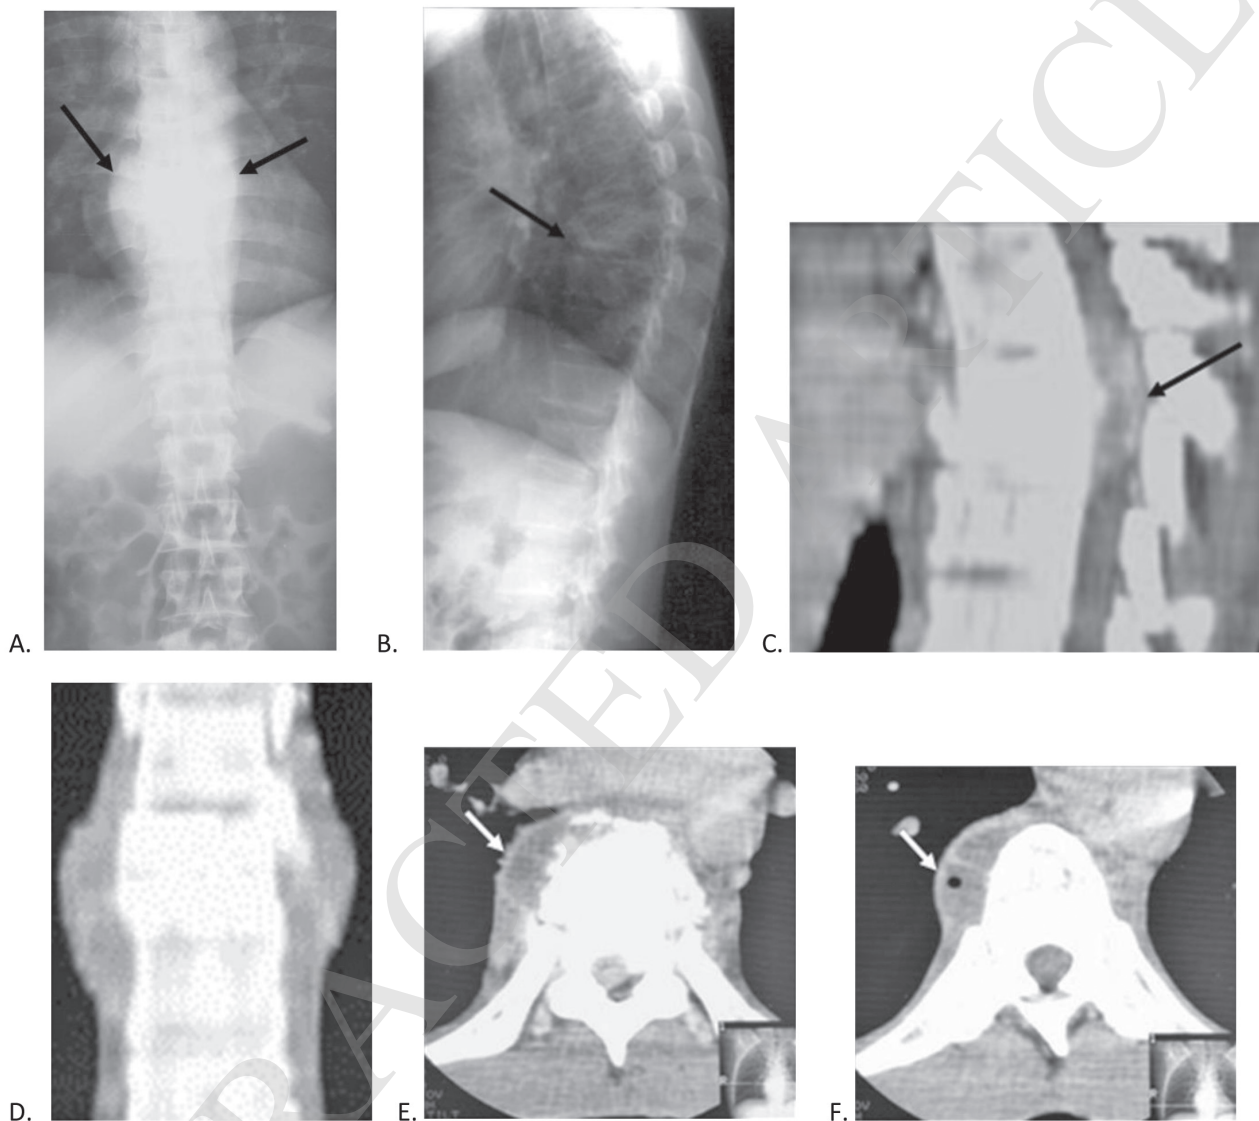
Tuberculous spondylitis. A 40-year-old woman presented with chronic kyphosis and paraplegia for 2 months. Anteroposterior (A.) and lateral (B.) views of plain radiographs show mild kyphotic deformity of the upper thoracic spine, a mildly collapsed T6 vertebra, narrowing of the T6-7 disc space with indistinct endplates, and bilateral paravertebral soft tissue lesions (black arrows). C. Postcontrast sagittal CT demonstrates the mildly collapsed T6 vertebra, involvement of the T6-7 disc space with large anterior epidural soft tissue (black arrows) compressing the thoracic cord. D. Postcontrast coronal CT confirms enhancing bilateral paravertebral soft tissues. E. and F. Postcontrast axial CT at T6-7 level demonstrates a large thin smooth rim enhancing lesion (white arrows) at the right-sided paravertebral region with internal small air bubble representing a tuberculous abscess. The patient underwent T6-7 laminectomy to decompress the spinal cord and evacuate the epidural soft tissue. The paravertebral abscess was surgically drained. Pus culture was positive for *M. tuberculosis*.
